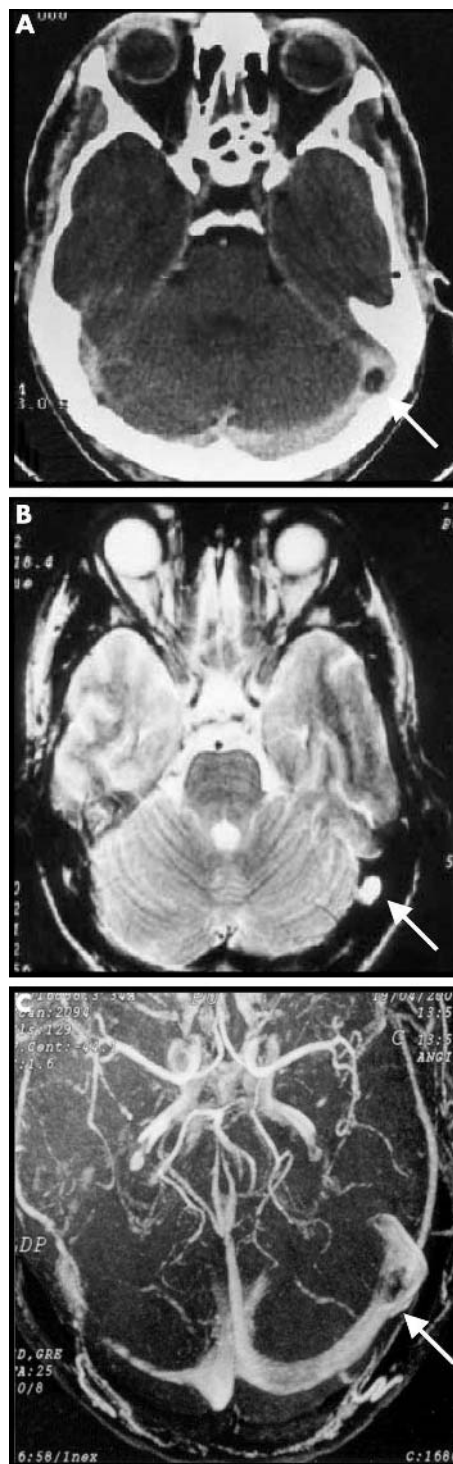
(A) Contrast enhanced CT showing slow emptying of the left transverse sinus with an image resembling an empty delta sign. (B) Fast spin echo T2 weighted MRI revealing a round, hyperintense signal in the left transverse sinus. (C) MRV showing a filling defect in the left transverse sinus, confirming the presence of a thrombus.
